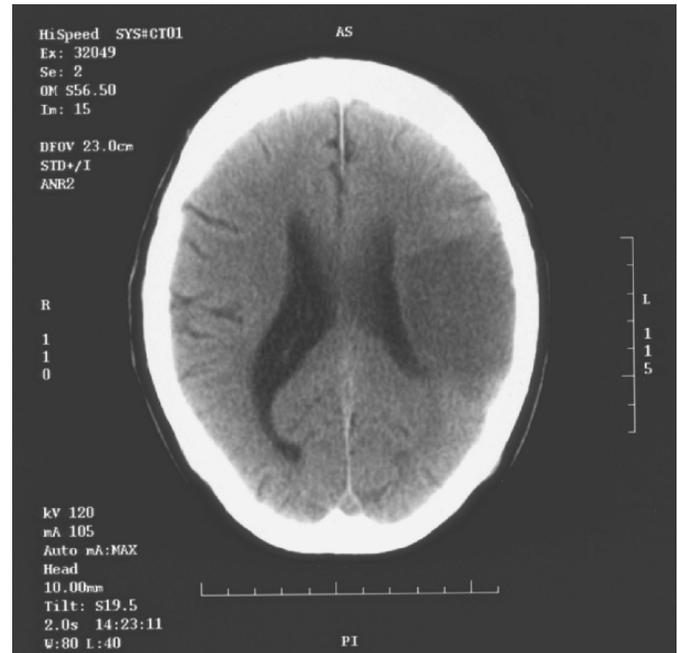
CT brain scan showing an area of low attenuation in the left temporal lobe consistent with an infarct
